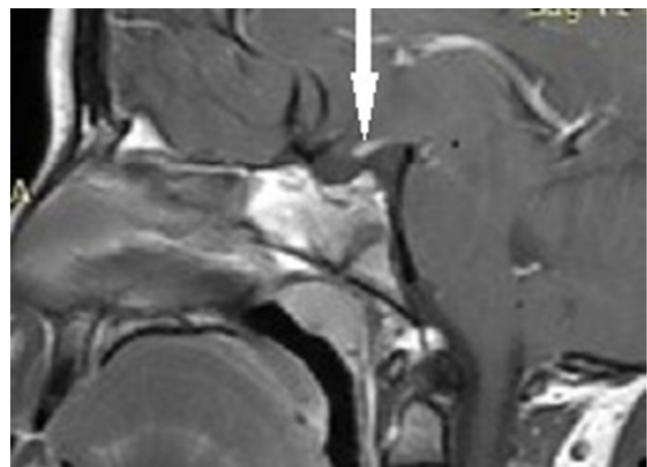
Sagittal T1-weighted image showing ectopic and high signal posterior pituitary.
